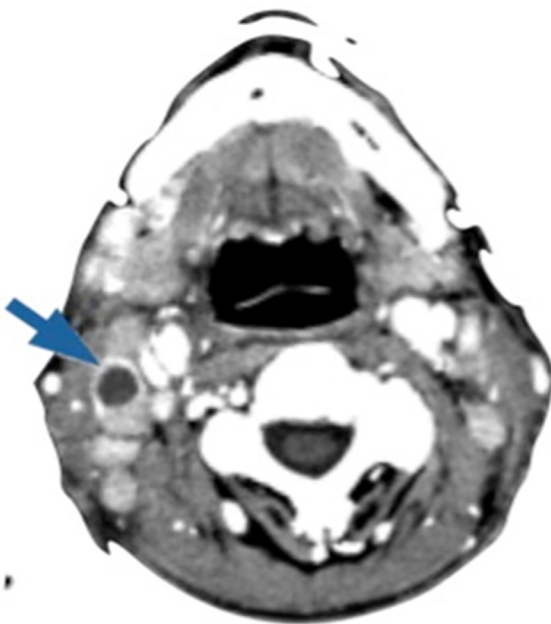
Computed tomography of the neck showing a cervical metastasis (arrow) of maxillary squamous cell carcinoma
